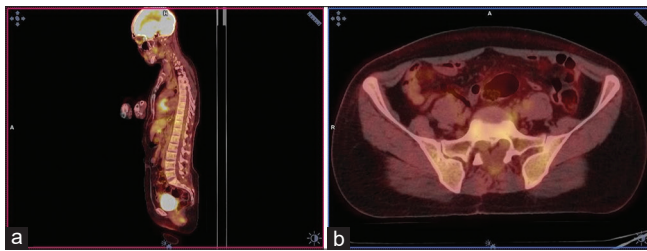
Positron emission tomography-computed tomography images of our patient. (a) Axial fused positron emission tomography-computed tomography of the pelvis (ganglioneuromas at the level of sacral neural foramen). (b) Sagittal-fused positron emission tomography-computed tomography image
